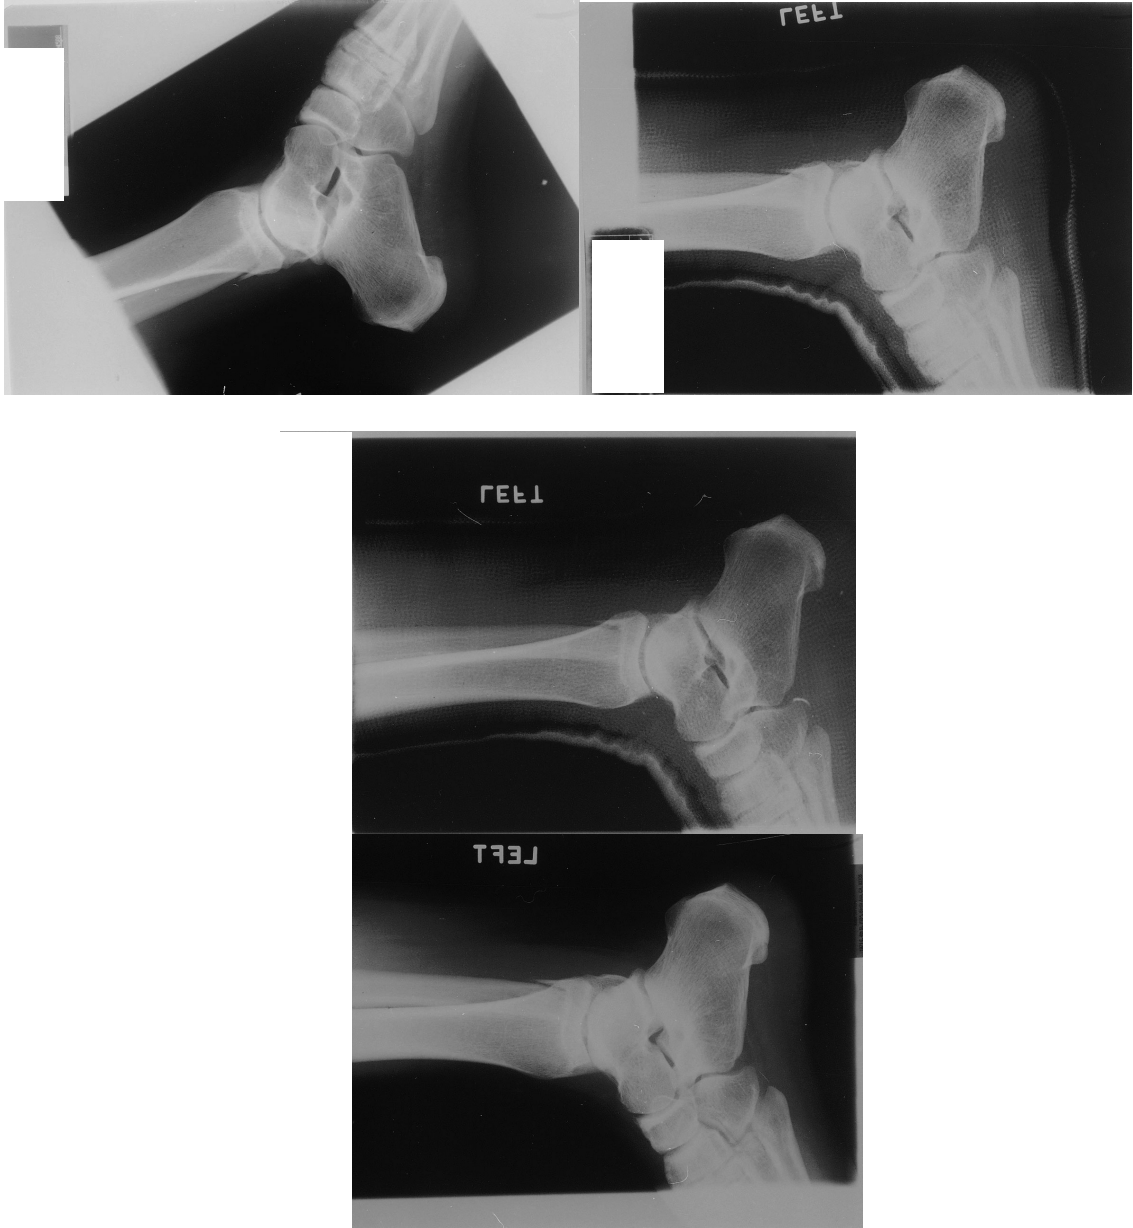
Radiographs from PWC File 3.
